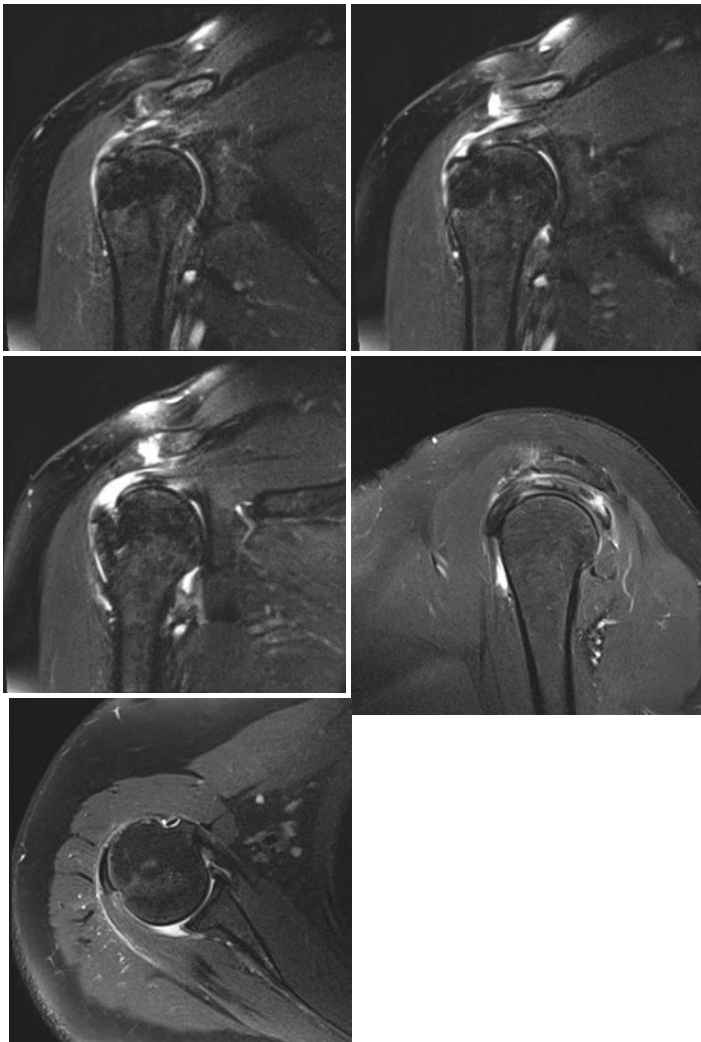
Magnetic resonance imaging of the right shoulder shows evidence of a full-thickness tear of the supraspinatus tendon. Additionally, the coronal cuts demonstrate increased signal within the superior labrum consistent with degenerative tearing, and the axial cuts show fluid around the long head of the biceps tendon consistent with tendinopathy
